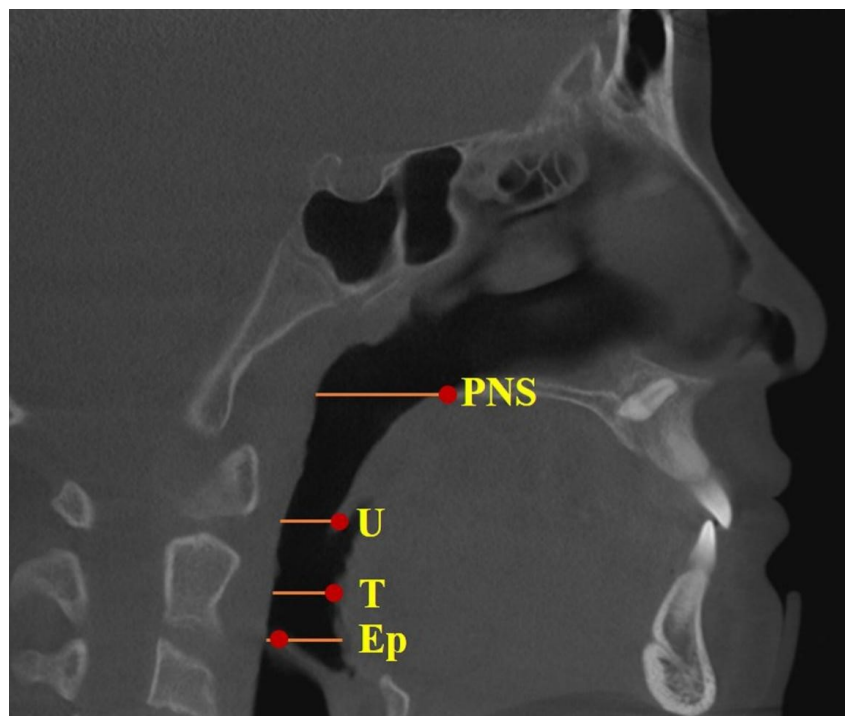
The CBCT cephalometric landmarks and lines on the midsagittal plane. Abbreviations: PNS plane, poster nasal spinous point plane; U plane, uvula apex point plane; T plane, the point at which the tongue root is closest to the posterior pharyngeal wall; Ep plane, epiglottis apex point plane; CBCT, cone beam computed tomography.
